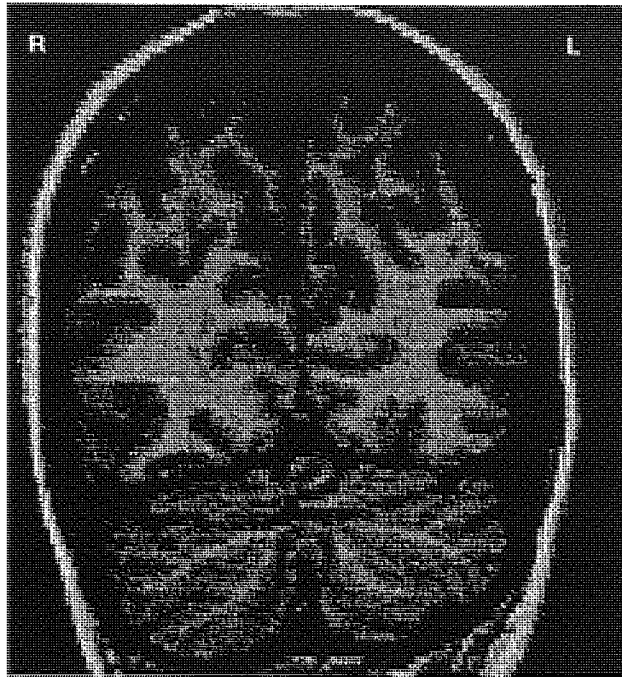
Vertical MRI section of subject FF. The calcarine fissure is highlighted in red.
